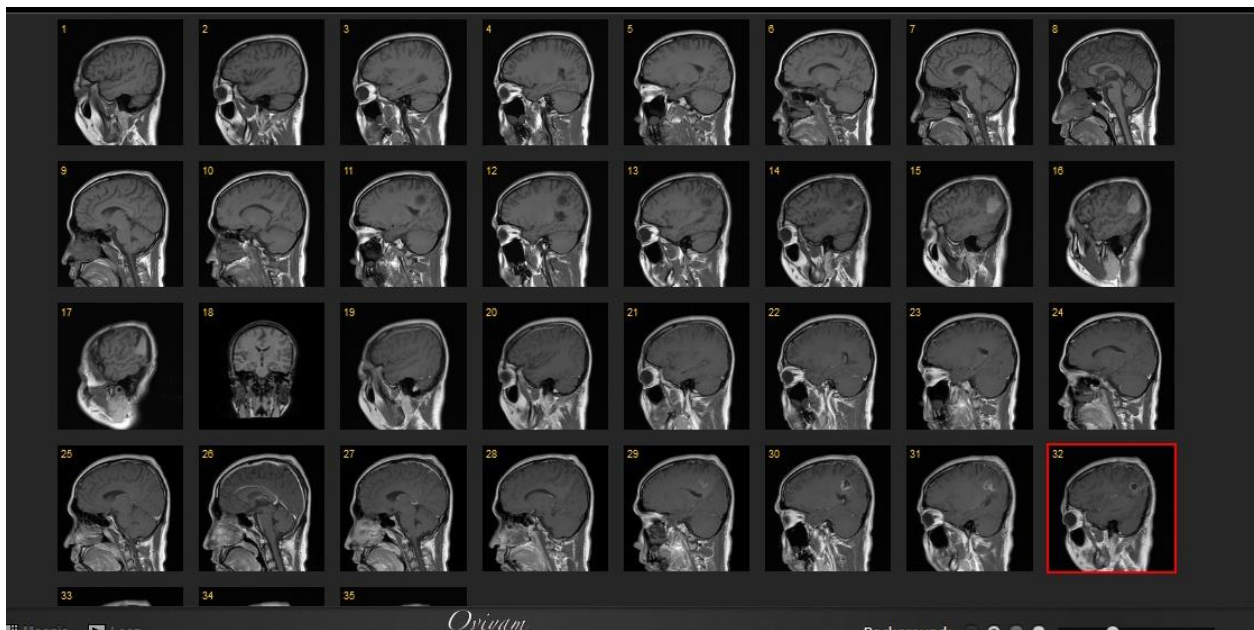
MRI of the Brain with Contrast (Sagittal View)
